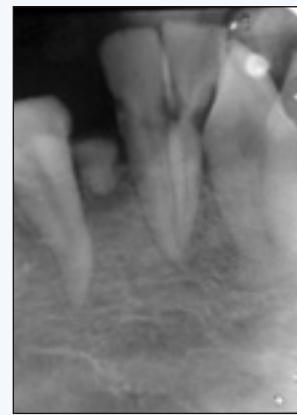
Periapical radiograph showing the over-retained tooth 83.
